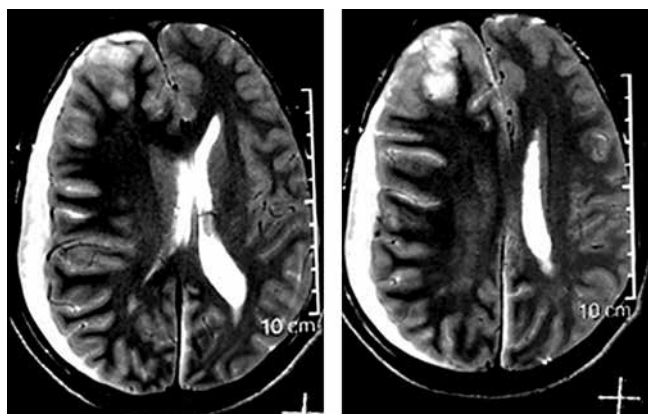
MRI T2 brain showing right subdural collection, mass effect and right frontal gliosis (red arrow)
